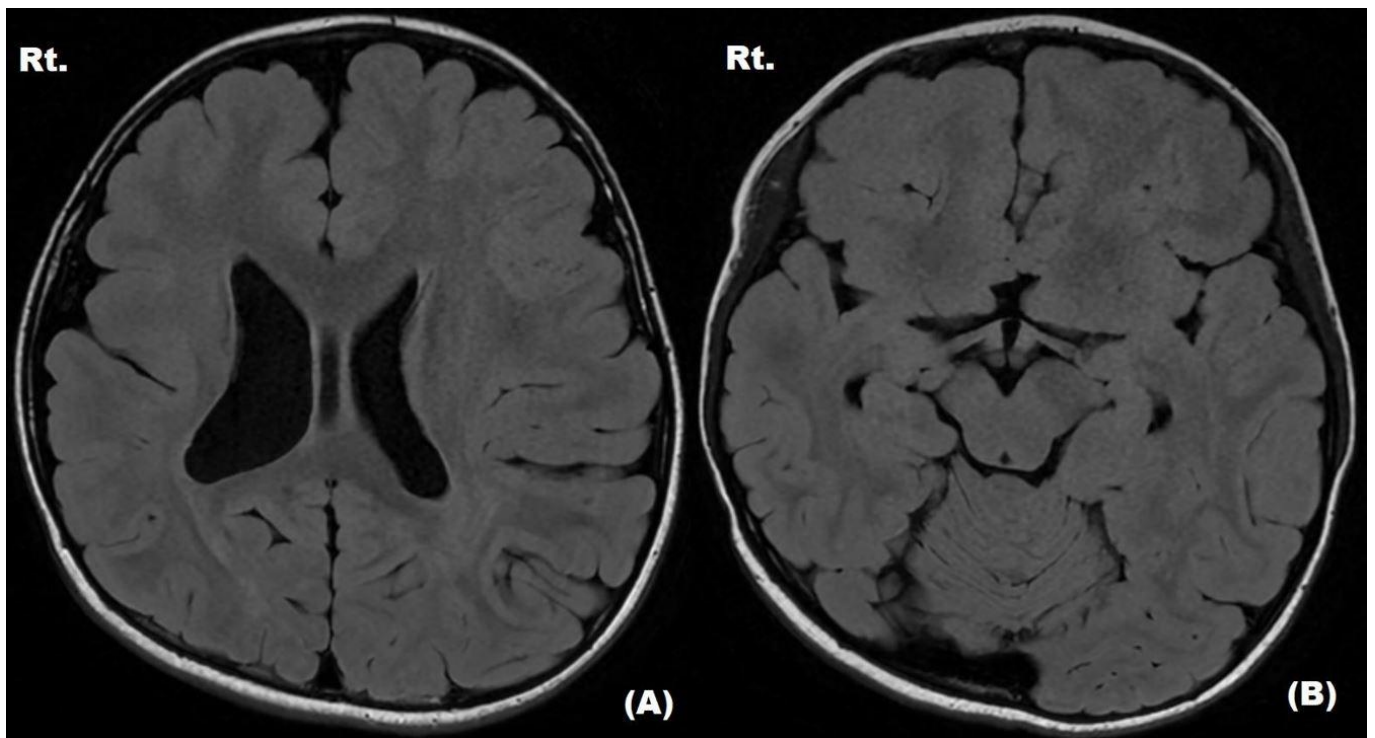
Brain MRI images taken when the patient was 8 years old. A-B) Axial T2-FLAIR images demonstrate diffuse cortical thickening and decreased volume of the right cerebral hemisphere, accompanied by lissencephaly affecting the entire right hemisphere.
